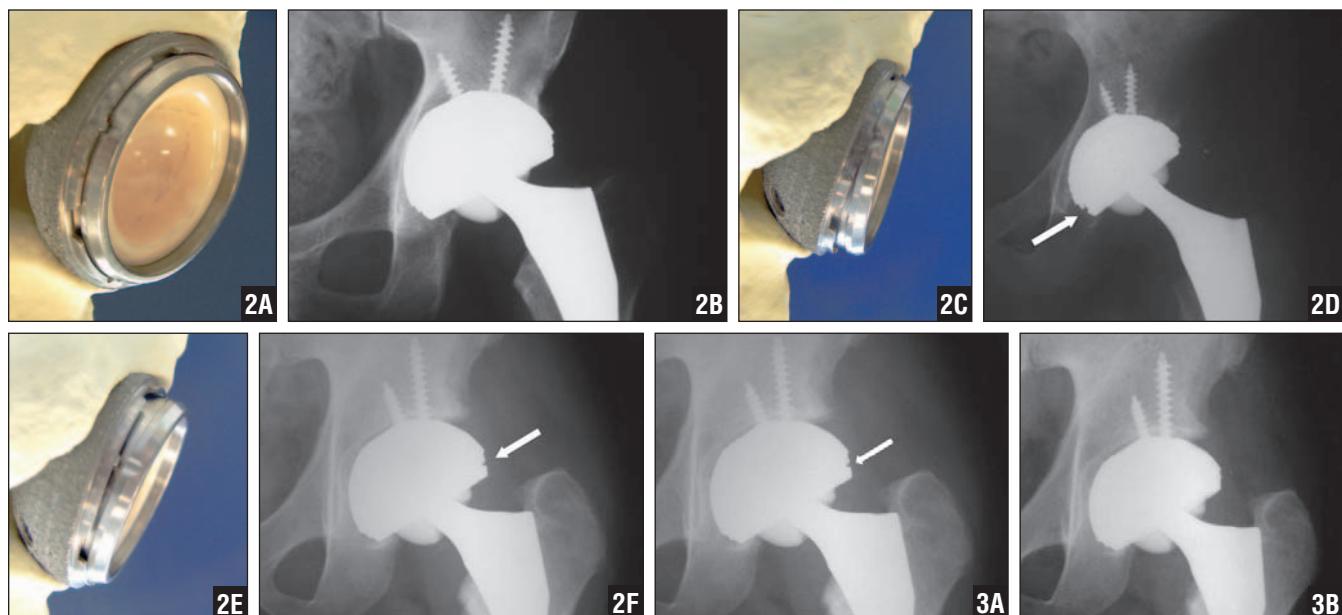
Representation of ceramic liner malseating based on the location of the gap in the liner–shell junction: complete seating (A, B); inferomedial malseating of the liner (C, D); superolateral malseating of the liner (E, F). Figure 3: Radiographic views of a patient who underwent primary THA with a metal-backed alumina liner housed in a titanium shell. Immediate postoperative radiograph showing superolateral malseating of the liner (A). Radiograph at 2-month follow-up showing subsequent seating of the ceramic liner (B).
